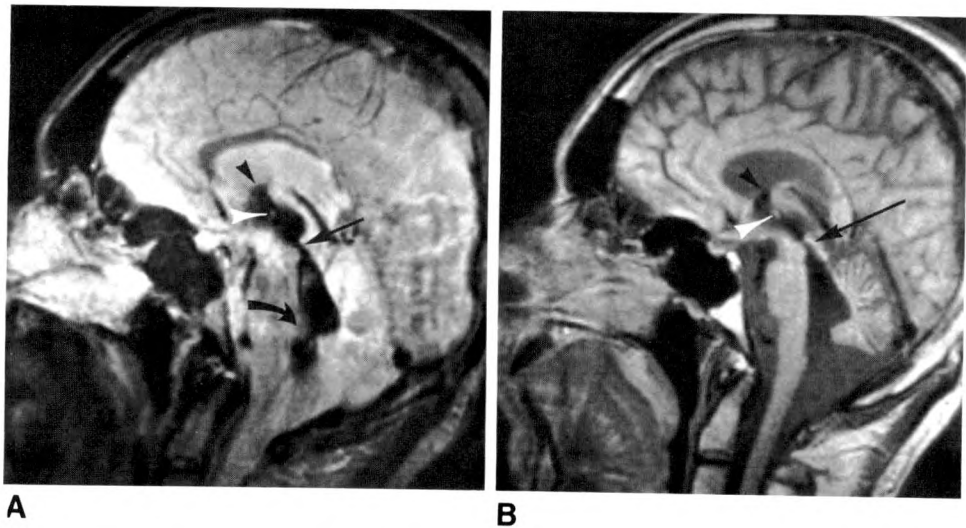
37-year-old man with inferior vermian dysgenesis and posttraumatic EVOH. Basilar subarachnoid spaces are enlarged. Midsagittal MR scans are 5 mm thick. A, T2-weighted scan (SE 2200/80). CSF in lateral ventricles is bright. Striking CFVS in foramina of Monro (black arrowhead), third ventricle, aqueduct of Sylvius (straight arrow), fourth ventricle, and foramen of Magendie (curved arrow). CFVS surrounds massa intermedia (white arrowhead). B, T1-weighted scan (SE 750/40). CFVS is less well seen but is present in foramina of Monro (black arrowhead), posterior third ventricle, aqueduct of Sylvius (arrow), and proximal fourth ventricle. Massa intermedia (white arrowhead).
